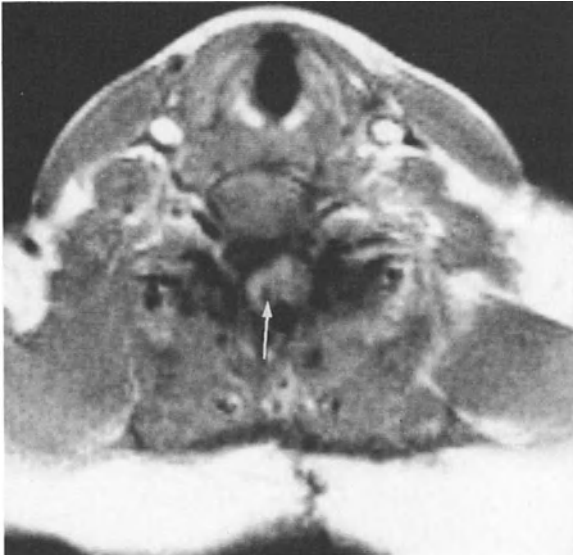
Typical MR appearance of tumor-associated syringomyelia on axial T1-weighted image (FLASH 400/14) before enhancement: Eccentric cavity position (*arrow*); uneven thickness of surrounding spinal cord. Hemangioblastoma (same patient as in Fig. 1)
